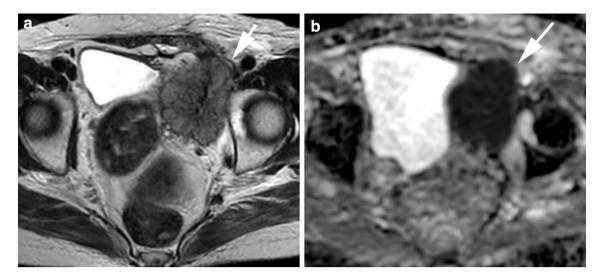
a Axial T2-weighted fast spin-echo magnetic resonance image shows left external iliac nodal metastasis (*arrow*). b Apparent diffusion coefficient (ADC) map shows restricted diffusion of the lesion (*arrow*)
